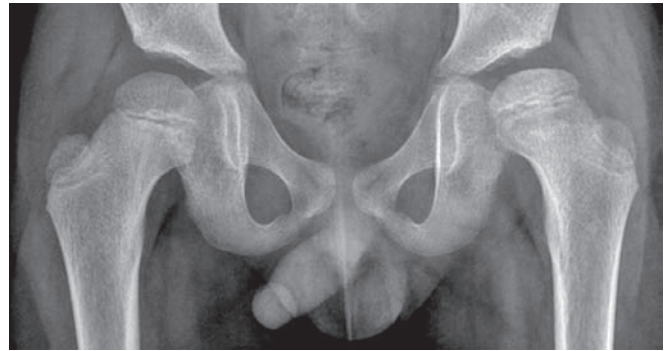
Radiographic appearance of a boy with Perthes' disease. The epiphysis is sclerotic and flattened
